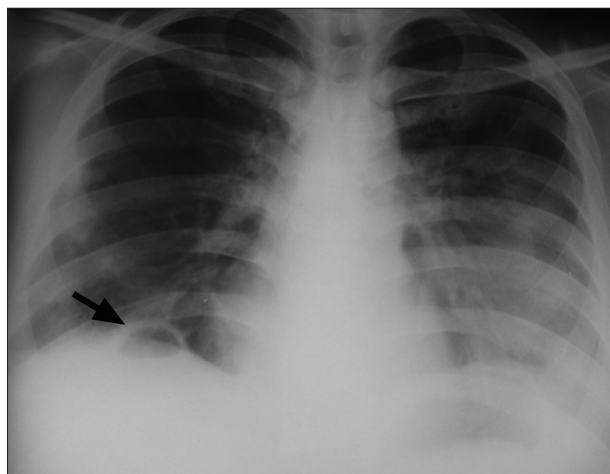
Chest radiograph showing multiple nodules (some with cavitation) and bilateral pleural effusion
